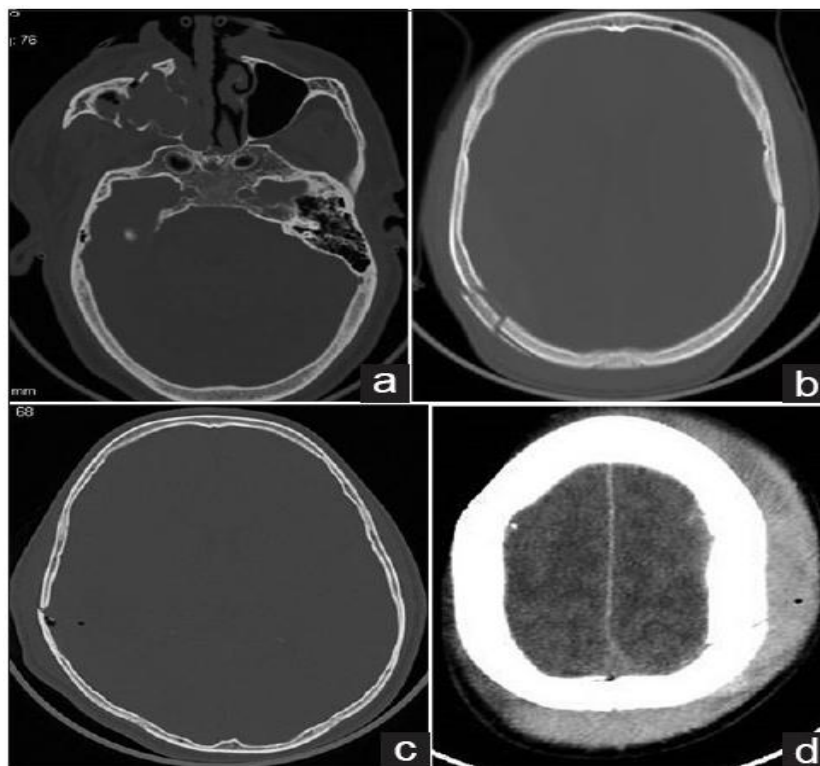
Axial cranial computed tomographic images from the study.
